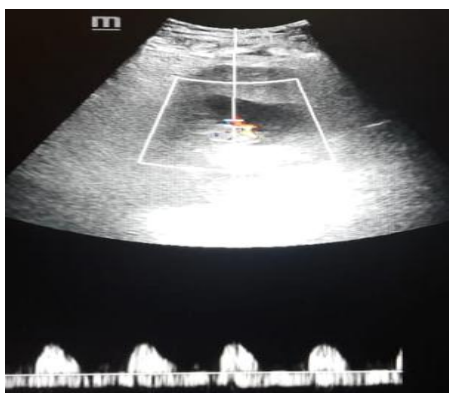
Ultrasonographie view of positive fetal activity in a patient at her 7th week of amenorrhea
